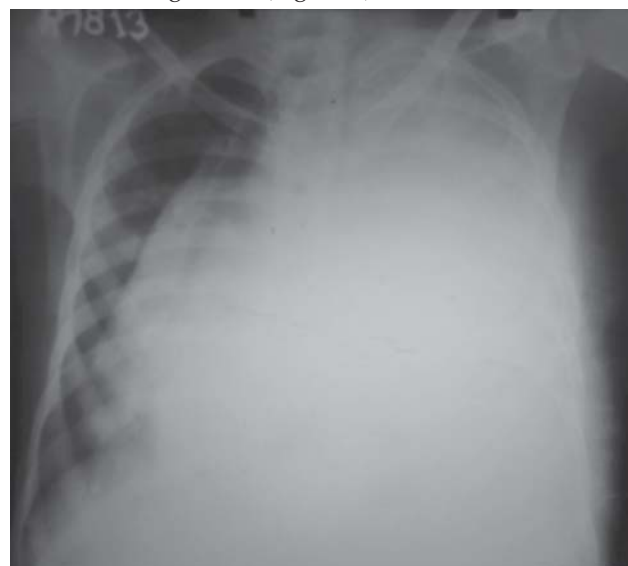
Chest radiograph (postero-anterior view) showing left-sided homogeneous opacity with tracheal and mediastinal shift towards the right.
